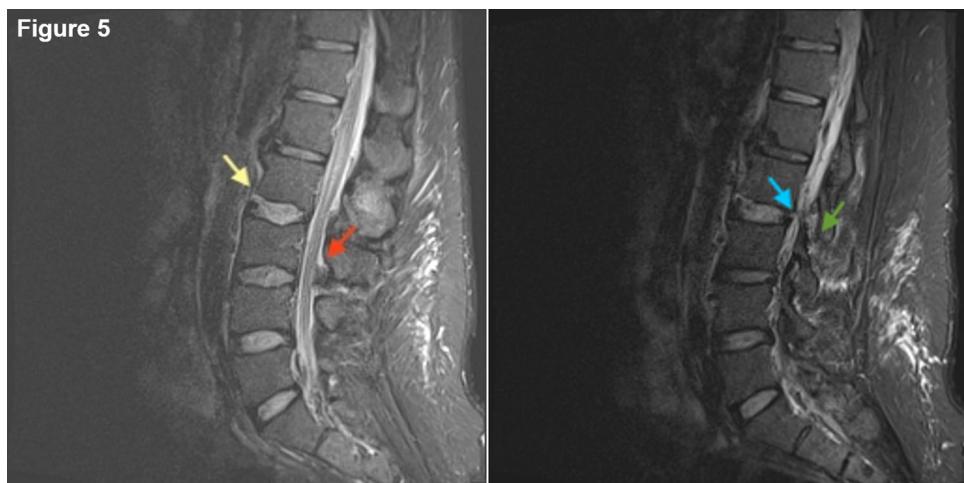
Sagittal T2-weighted short tau inversion recovery magnetic resonance imaging showing signal change indicative of injuries of the anterior longitudinal ligament and annulus fibrosus (left, yellow arrow), posterior longitudinal ligament (right, blue arrow) and ligamentum flavum (left, red arrow). Facet distraction can also be seen at L2/L3 interval (right, green arrow). There is also high signal intensity denoting inflammation at posterior subcutaneous tissue
